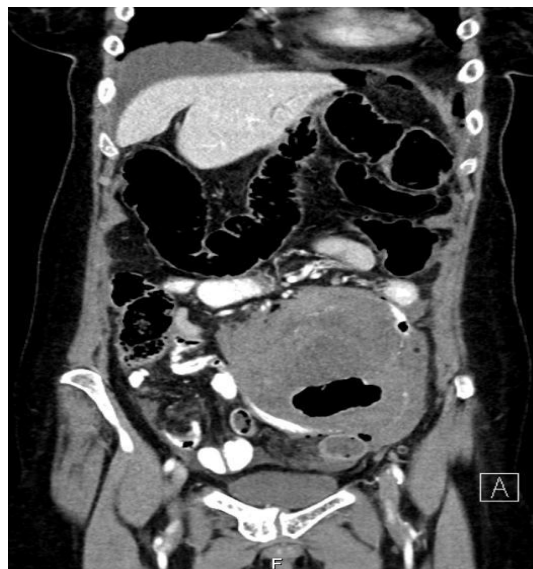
a coronal contrast enhanced Computed Tomography showing large tumor of 12 cm diameter at left mid-lower abdomen, with free intra-abdominal air and fluid.
